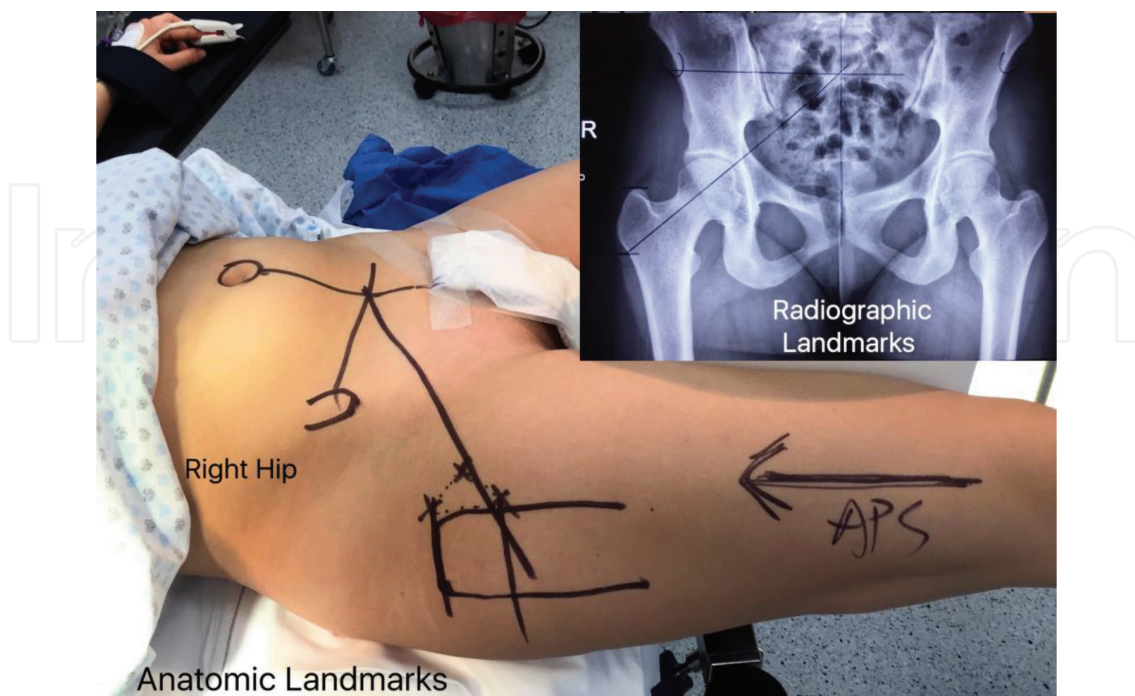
Radiographic landmarks (right upper corner X ray) and anatomic landmarks plotted in the patients right hip.
